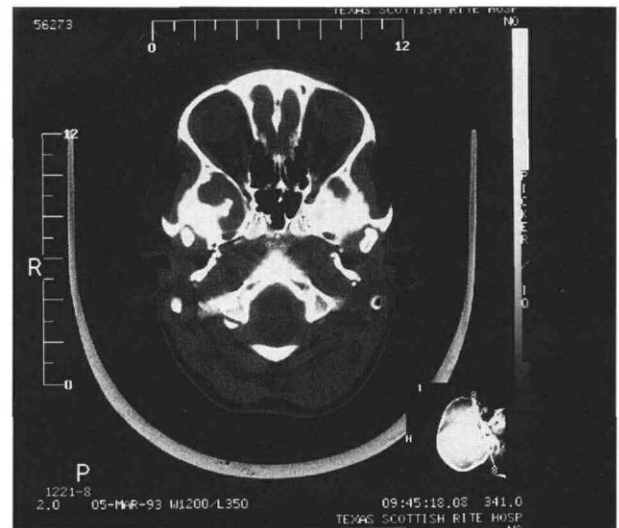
CT scan of a JRA patient showing the condyle in axial view with the largest condylar dimension. Note the reduced cross-sectional areas of the condyles and the ill-defined cortices.
